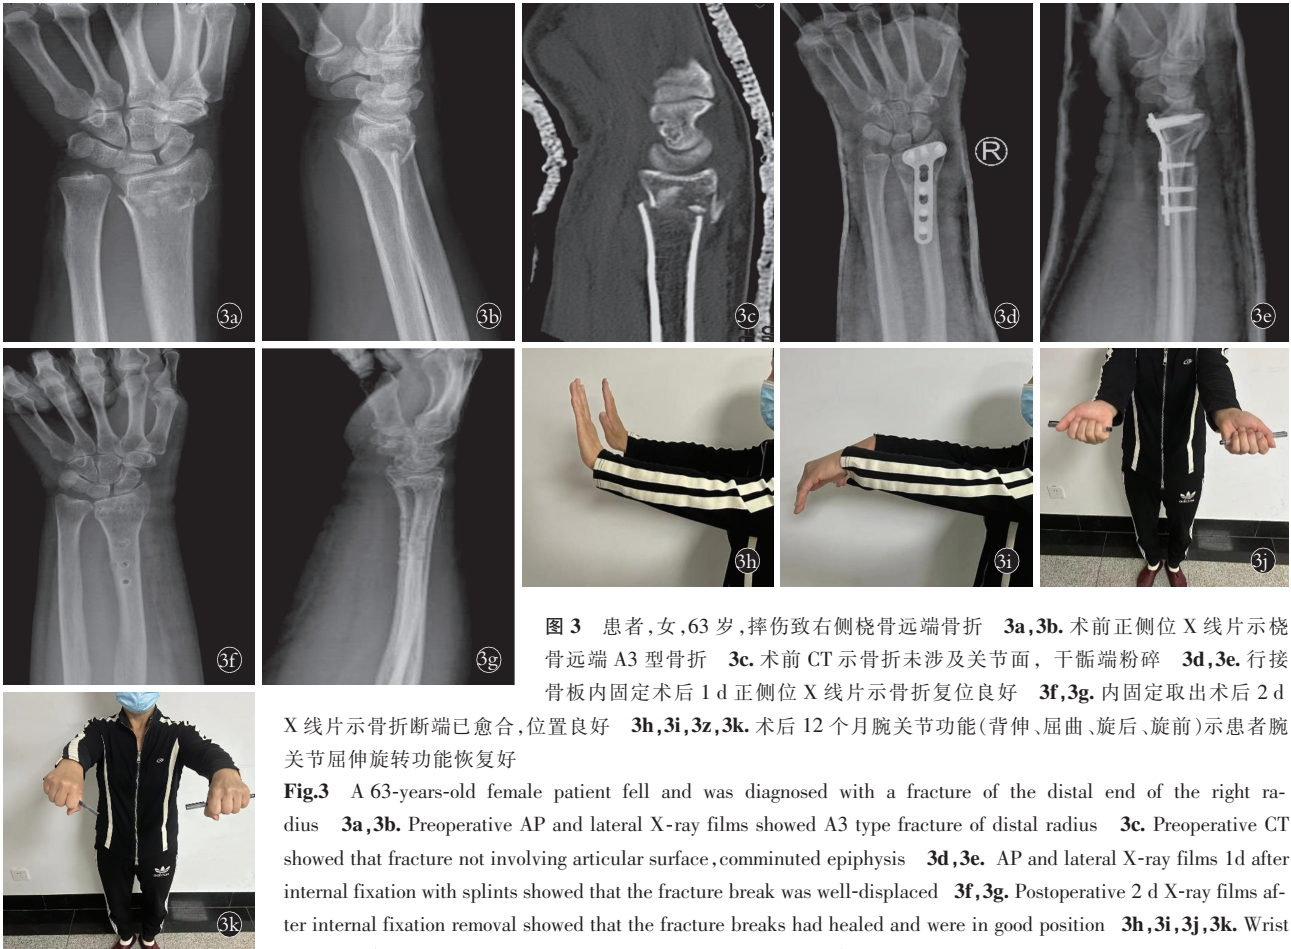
患者,女,63 岁,摔伤致右侧桡骨远端骨折 3a,3b. 术前正侧位 X 线片示桡骨远端 A3 型骨折 3c. 术前 CT 示骨折未涉及关节面,干骺端粉碎 3d,3e. 行接骨板内固定术后 1 d 正侧位 X 线片示骨折复位良好 3f,3g. 内固定取出术后 2 d X 线片示骨折断端已愈合,位置良好 3h,3i,3j,3k. 术后 12 个月腕关节功能(背伸、屈曲、旋后、旋前)示患者腕关节屈伸旋转功能恢复好
